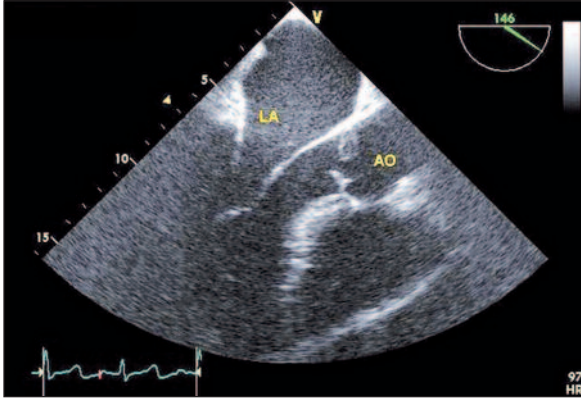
Transesophageal echocardiography in aortic long-axis view reveals perforation in the right coronary cusp.
